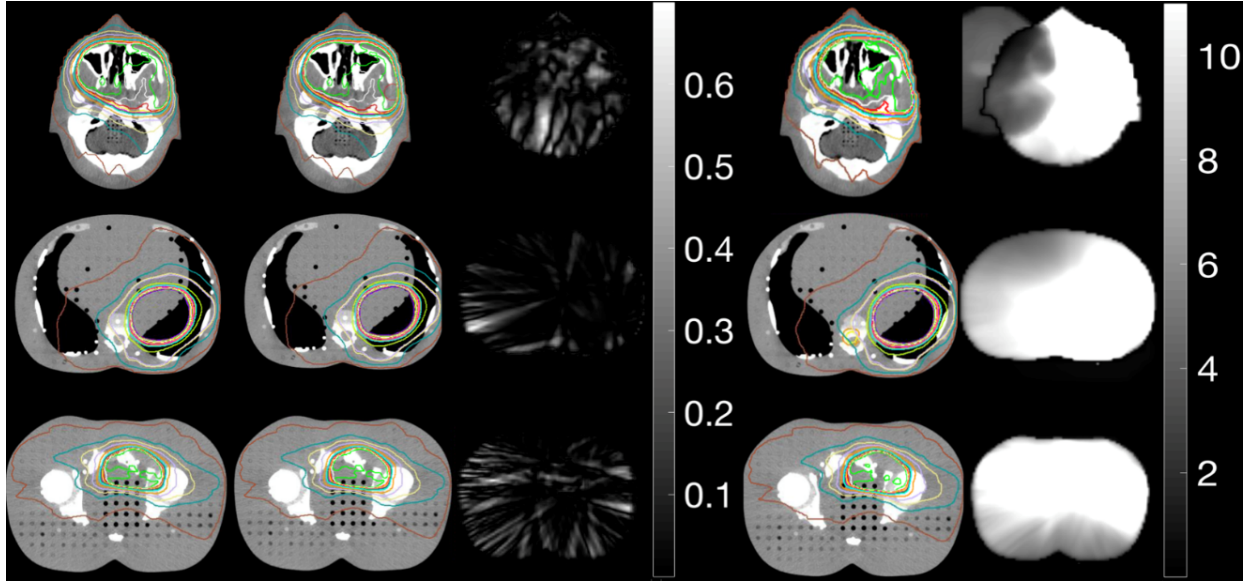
Axial view of dose calculated on shifted planning CT (1st column), VMAT-CT+ (2nd column), and CBCT (4th column), and 3D Gamma plot (3rd and 5th columns) (planning CT is used as the reference) for a head plan (top row), an abdomen plan (middle row), and a prostate plan (bottom row).
